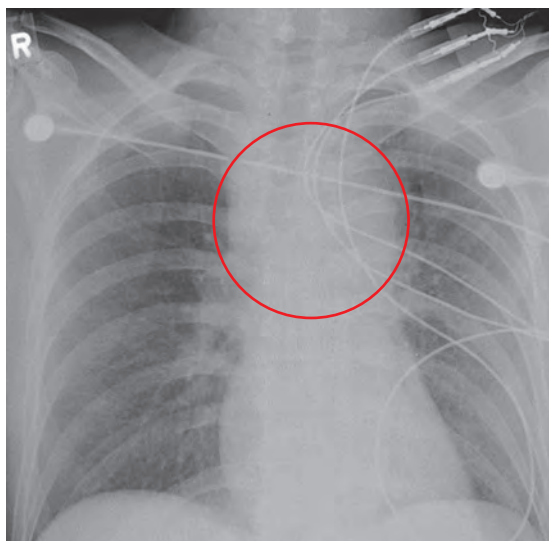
Chest radiograph taken on hospital admission. Note the widened mediastinum (area enclosed by the red circle). This finding is suggestive of a thoracic aortic syndrome. Although a chest radiograph may be suggestive, it is important to remember that a normal chest radiograph does not reliably rule out major thoracic aortic pathology.
